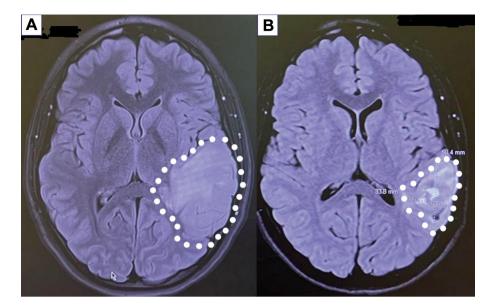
MRI images of the brain of a 16-year-old girl with high grade glioma. A) The tumor was located in the left temporal lobe with compression of the left lateral ventricle and narrowing of left temporal lobe sulci before the start of treatment in July 2022. The patient began methionine restriction with o-rMETase and a low-methionine diet along with TMZ (75 mg/m²) combined with radiotherapy in August 2022. After completion of radiotherapy, the dose of TMZ was increased to 150 mg/m³. B) The tumor shrunk with improvement of the left lateral ventricle and left temporal lobe sulci in March 2023. o-rMETase: Oral recombinant methioninase; TMZ: temozolomide.
